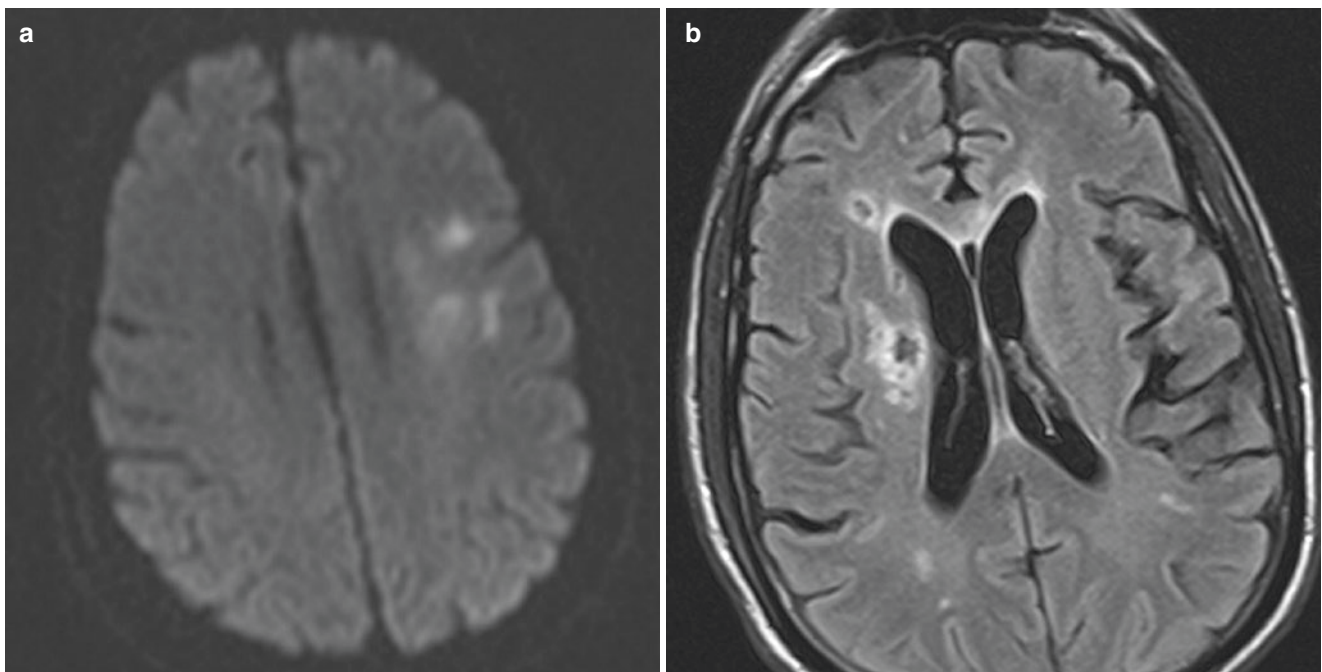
Primary angiitis of CNS. A 35-year-old with progressive weakness and mental status decline. (a) DWI shows an acute to subacute infarction in the left corona radiata. (b) Axial FLAIR shows several additional chronic lacunar infarctions most prominent in the right basal ganglia. (c, d) 3D TOF MRA axial (c) and sagittal (d) reformations
